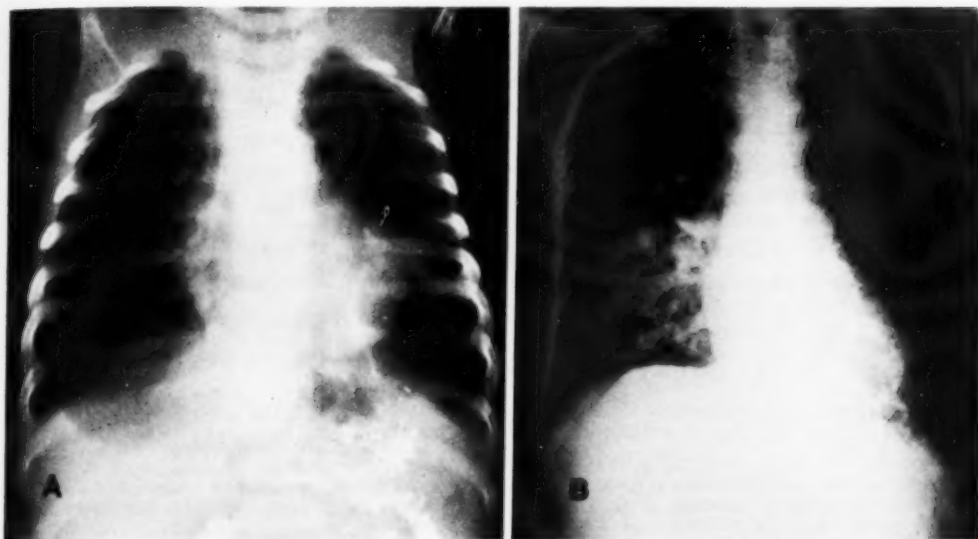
Honeycomb lungs. A. Extensive bilateral fibrocystic emphysema occurring in honeycomb lung in infancy before severe infection has occurred. The plain film findings of the congenital and acquired types are indistinguishable. B. At a later age honeycomb lungs are complicated by infection, as shown in this case. There are confluent areas of pneumonic density and interstitial scarring. The multiple cystic cavities enlarge and diffuse areas of greater rarefaction develop.
